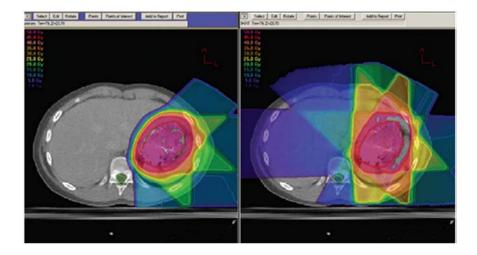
Comparative treatment plans for protons (left) and X-rays (right) in a liver treatment.
